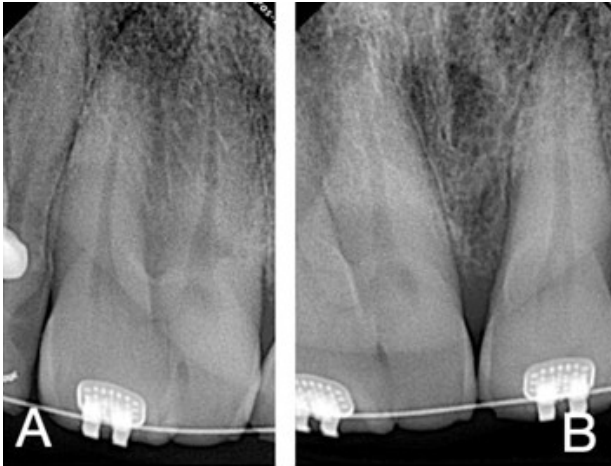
Periapical radiograph for right fused teeth (A), and for left central incisor (B).
